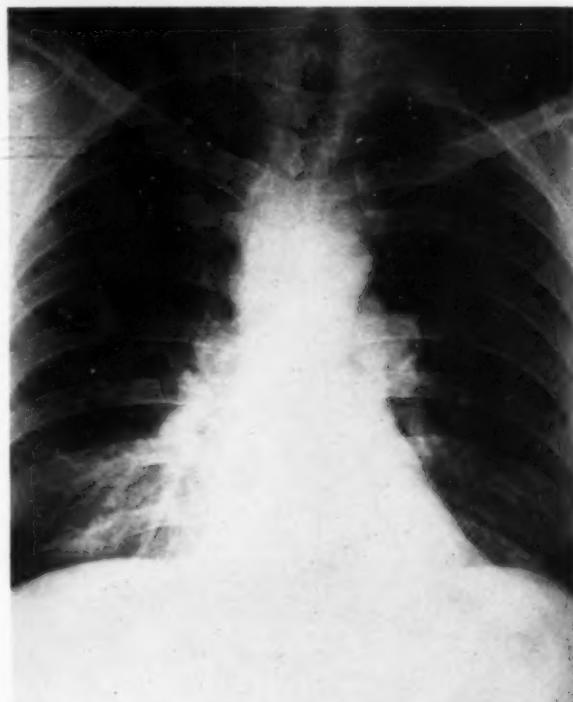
Roentgenogram of Case 2 showing right superior mediastinal mass with bilateral lymphadenopathy.
